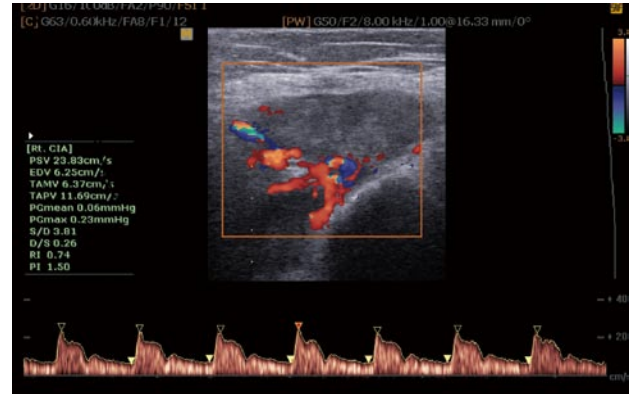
Color and spectral waveform Doppler ultrasonogram of the ischial tuberosity in a patient with severe enthesopathy with a mean resistive index of 0.74 before treatment.
